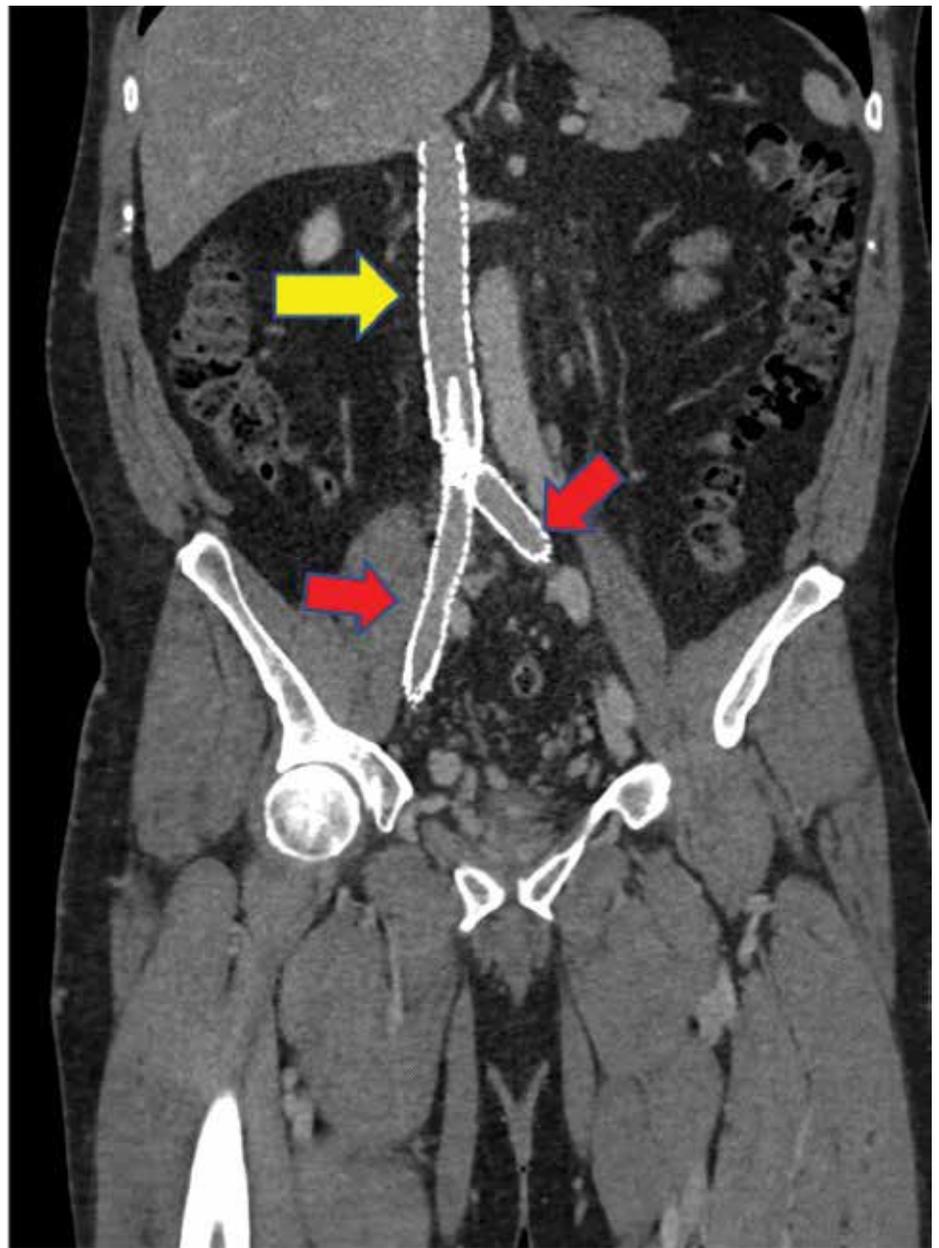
Follow-up CT scan showing patent inferior vena cava (yellow arrow) and bilateral common iliac vein (red arrows) stents.
